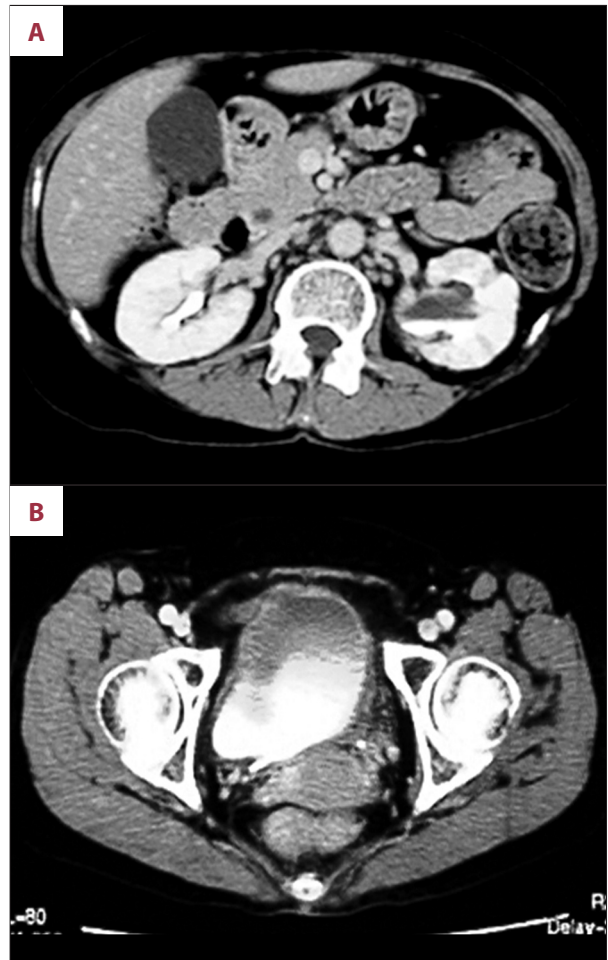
Abdominal CT scan. (A) Dilated calyces of the left kidney and decreased contrast excretion. Enlargement of left para-aortic lymph nodes. (B) Bladder mucosal enhancement and wall-thickening.
